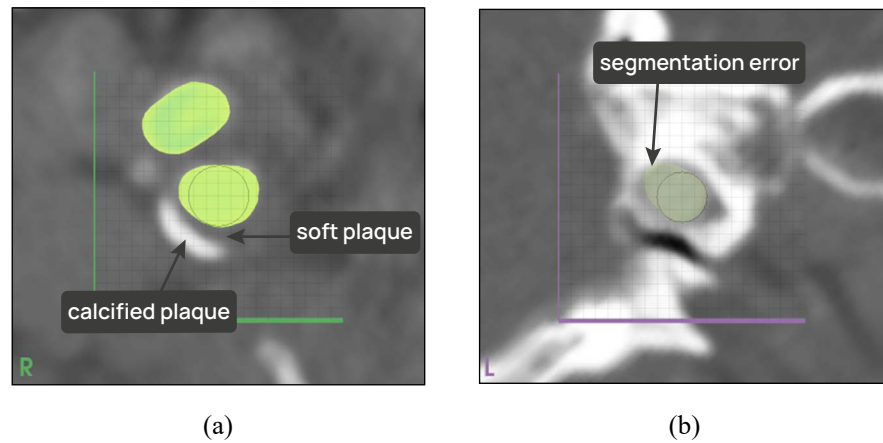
The probe can also sample the CTA volume. This allows to (a) assess plaque and (b) validate the segmentation at crucial locations.
